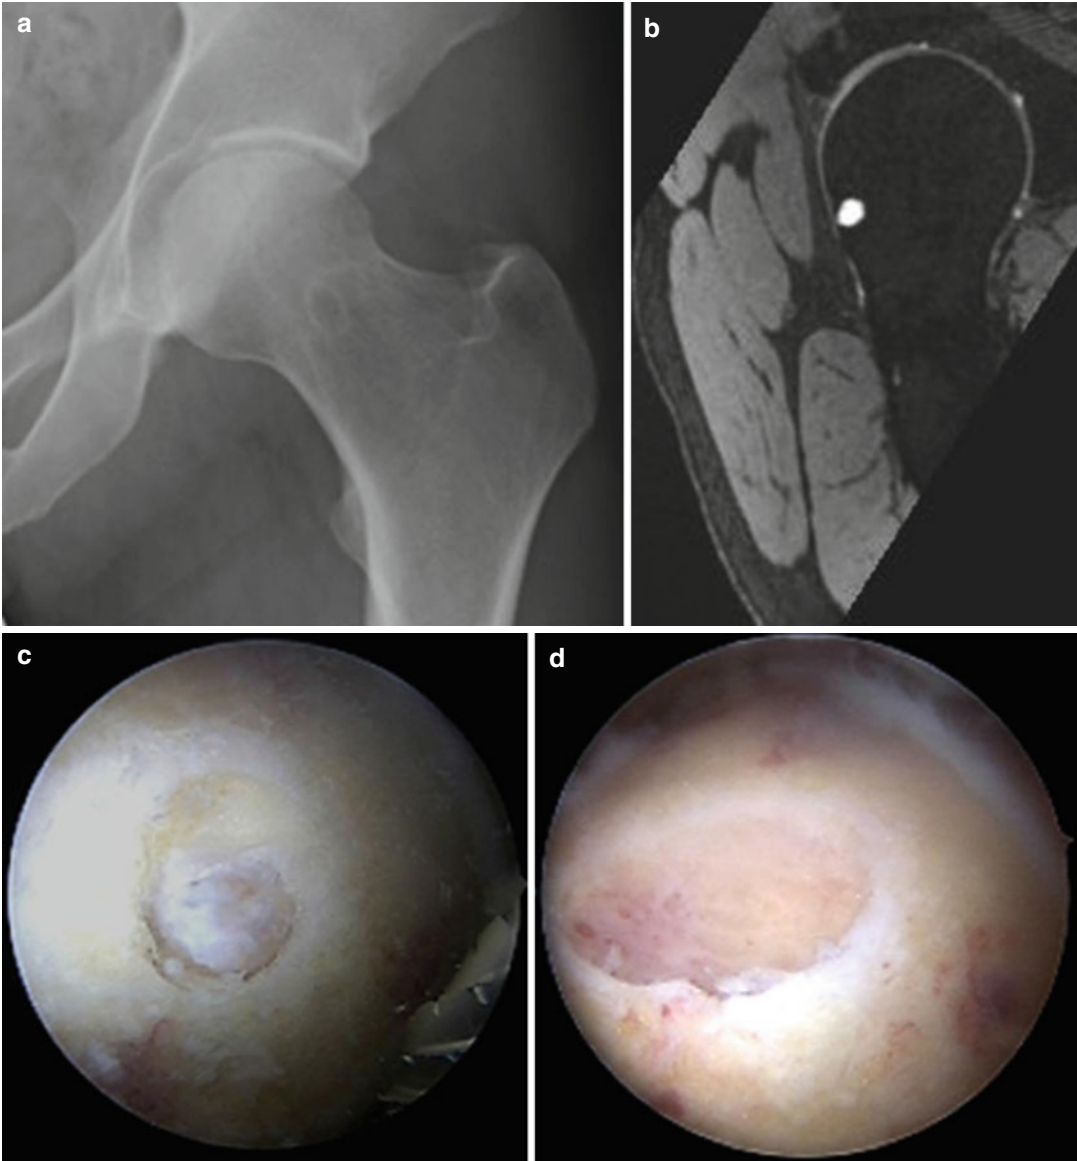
(a–d) Showing a herniation cyst in a case of FAI. Correlating the relative position of the cyst as seen on radiograph and MRI with the arthroscopic finding gives
